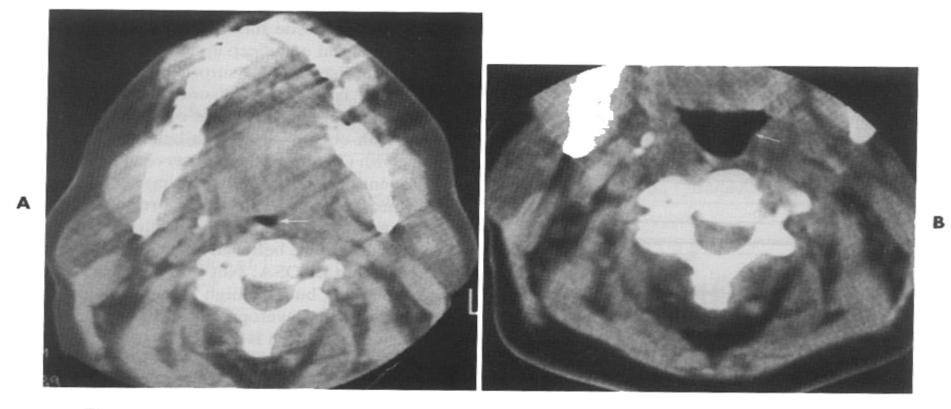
A, Computed tomography scan of oropharyngeal area demonstrating narrow lumen (arrow). B, Same patient after enlargement of oropharyngeal area by uvulopalatoplasty. Note enlargement of oropharyngeal airway. (From Thawley SE, Shepard JW. Understanding of the sleep apnea syndrome: causes and treatment, VA Practitioner 2:60, 1985.)
